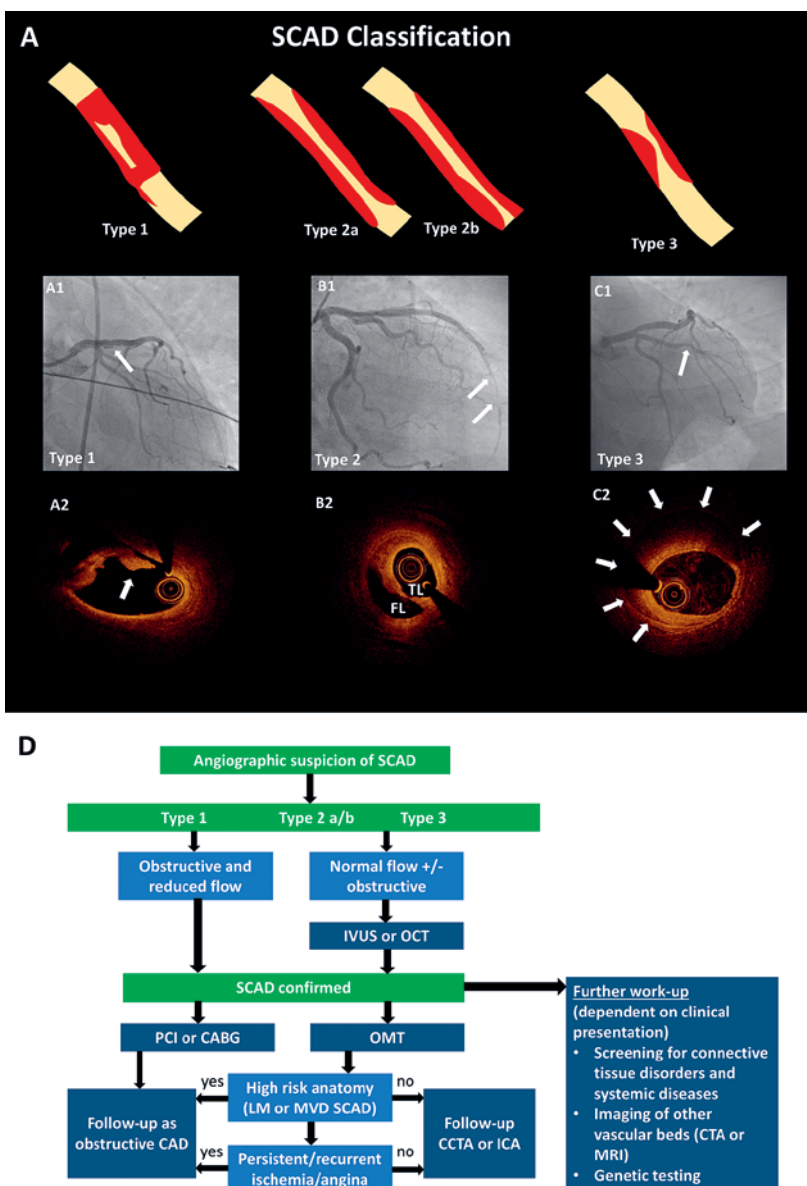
SCAD: Classification and Diagnostic algorithm. A) SCAD classification. A1) Type 1 SCAD with typical double lumen contour on angiography and intimal flap on OCT (A2). B1) Type 2b SCAD with visualization of the true lumen (TL) and false lumen (FL) on OCT (B2). C1) Type 3 SCAD with intramural hematoma on OCT (B3). D) Diagnostic algorithm for SCAD. CABG = coronary artery bypass grafting, CAD = coronary artery disease, CCTA = coronary computed tomography angiography, CTA = computed tomography angiography, ICA = invasive coronary angiography, IVUS = intravascular ultrasound, LM = left main, MRI = magnetic resonance imaging, MVD = multivessel disease, OCT = optical coherence tomography, OMT = optimal medical therapy, PCI = percutaneous coronary intervention, SCAD = spontaneous coronary artery dissection.
